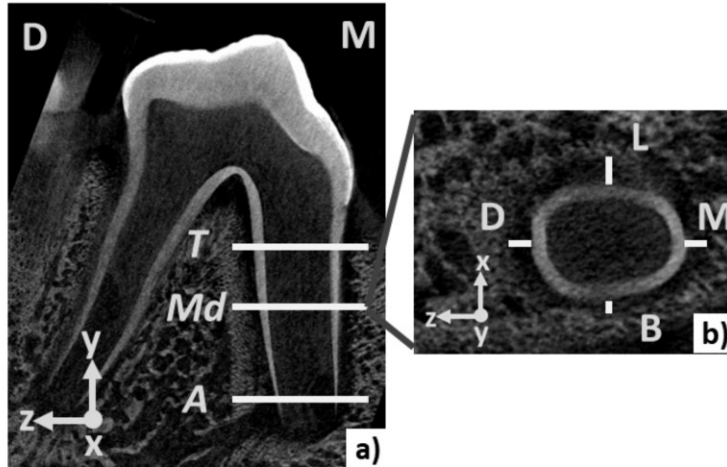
a) Representative  $\mu$ CT scan slice of a left second premolar indicating the Apex (A), Middle (Md), and Top (T) levels of the root where measurements were taken. b) Coronal slice indicating the Lingual (L), Mesial (M), Buccal (B), and Distal (D) direction where measurements were taken.
